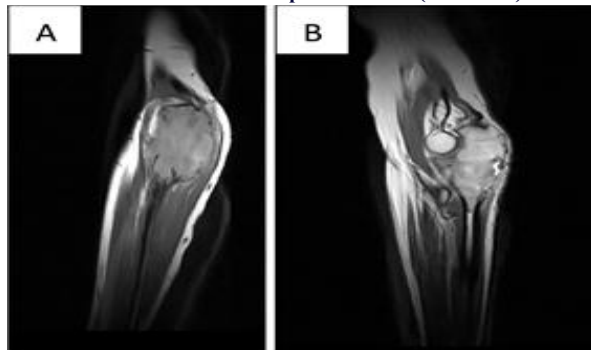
(A-B): A 25-year-old female with a GCT of the left proximal ulna. Radiography demonstrates the hallmark epi-metaphyseal location extending to about the subchondral articular surface. MRI confirms a highly vascular, solid tumor.
